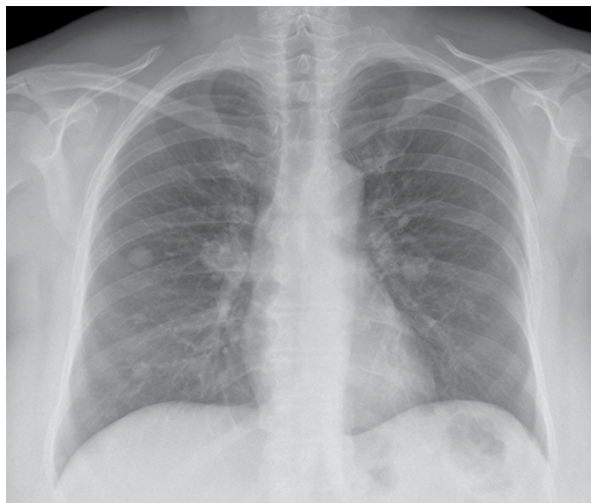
Posteroanterior chest radiograph showing multiple, round nodules in the middle and lower fields of both lungs
